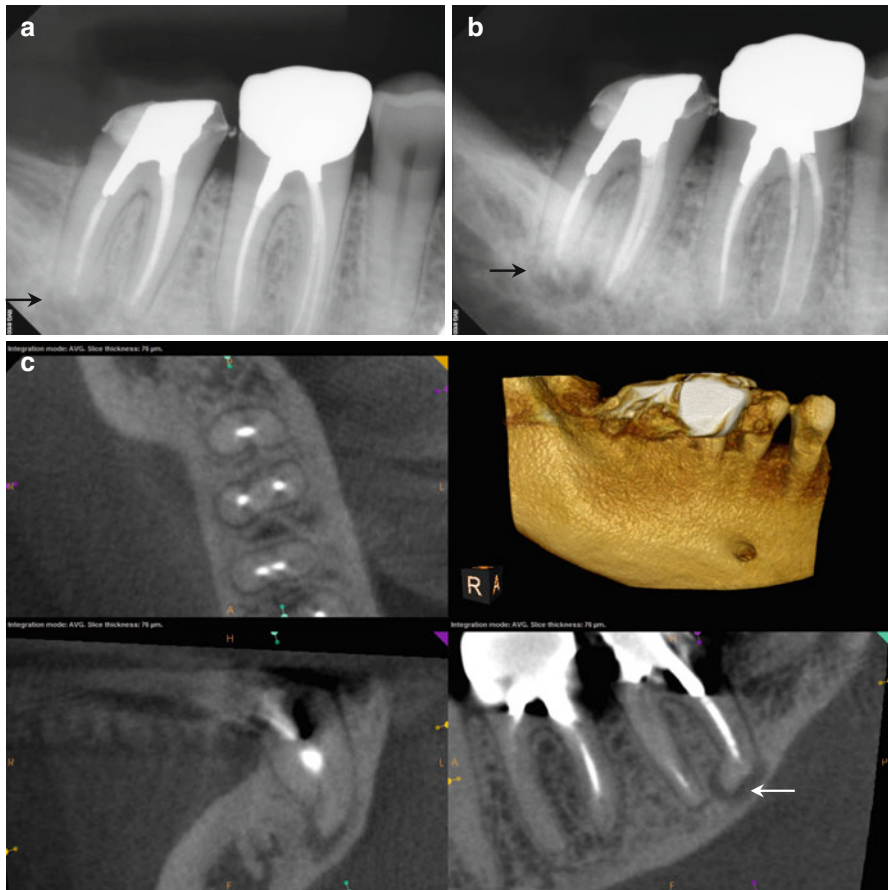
(a, b) Preoperative radiographs confirm the presence of a periapical area on the distal root apex of #31 (*black arrows*). There is also a cast post/core cemented in the distal canal and must be removed prior to retreatment. (c) Preoperative CBCT scan discloses a sharp dilacerations of the distal root apex toward the mesial (*white arrow*). There is also a low-density area associated with this dilaceration, most likely the result of residual tissue in this root segment. (d) The colorized sagittal section has been magnified to highlight the dilacerated root segment and associated area (*yellow arrows*). This segment is too sharply bent and too abrupt for conventional rotary instruments; after harvesting the root canal filling materials, this section of the distal root canal will be negotiated and instrumented using conventional hand files. This should minimize the chance of a separation event. (e, f) Final posttreatment radiographs demonstrating the extrusion of softened gutta-percha into the sharp dilacerations (*black arrows*). Prior knowledge of the angle and direction of this small dilaceration enabled the successful negotiation and cleaning of this small, but crucial, space
